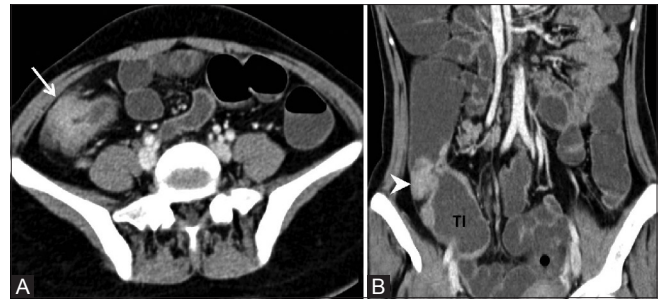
(A and B): Axial (A) and coronal (B) computed tomography enterography images of ileocecal tuberculosis showing gross thickening of ileocecal valve (arrow) and thickening and contraction of cecum (arrow head) with pericecal fat stranding. Terminal ileum (TI) is dilated
